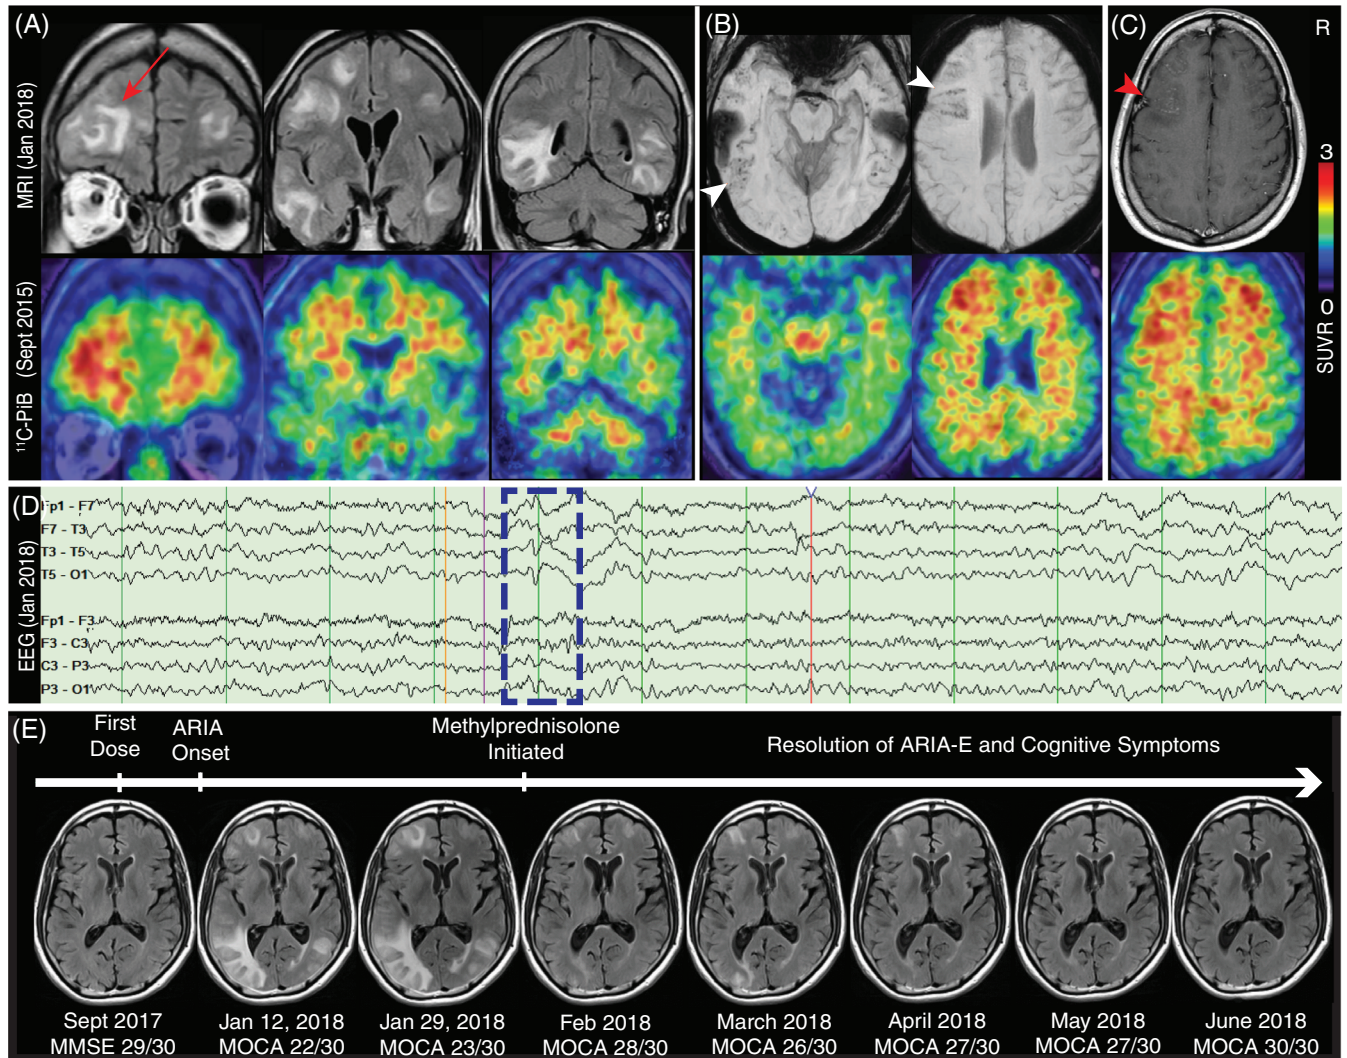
Amyloid-related imaging abnormalities (ARIA) after treatment with aducanumab. A, T2 fluid-attenuated inversion recovery (FLAIR) sequences (top) demonstrating ARIA-E after treatment with aducanumab, compared to 2015 ^{11}C -Pittsburgh Compound B (^{11}C -PiB) positron emission tomography (PET; bottom); red arrow highlights edema in area of high amyloid signal in left frontal pole. B, Susceptibility weighted imaging sequence demonstrating ARIA-H (top), compared to 2015 ^{11}C -PiB PET (bottom); white arrowheads indicate microhemorrhages in left frontal and temporal lobes. C, Post-contrast T1 sequence (top), compared to 2015 ^{11}C -PiB PET (bottom); red arrowhead indicates nodular enhancement in left frontal lobe. D, Electroencephalogram with left temporal sharps and after-going slow waves (dotted blue box), maximal electronegativity at T3 with field to T1, F7, T5, and O1. E, Sequential T2 FLAIR at the level of maximal edema, with subsequent resolution after treatment with intravenous steroids, with cognitive assessment showing resolution in parallel with ARIA-E
